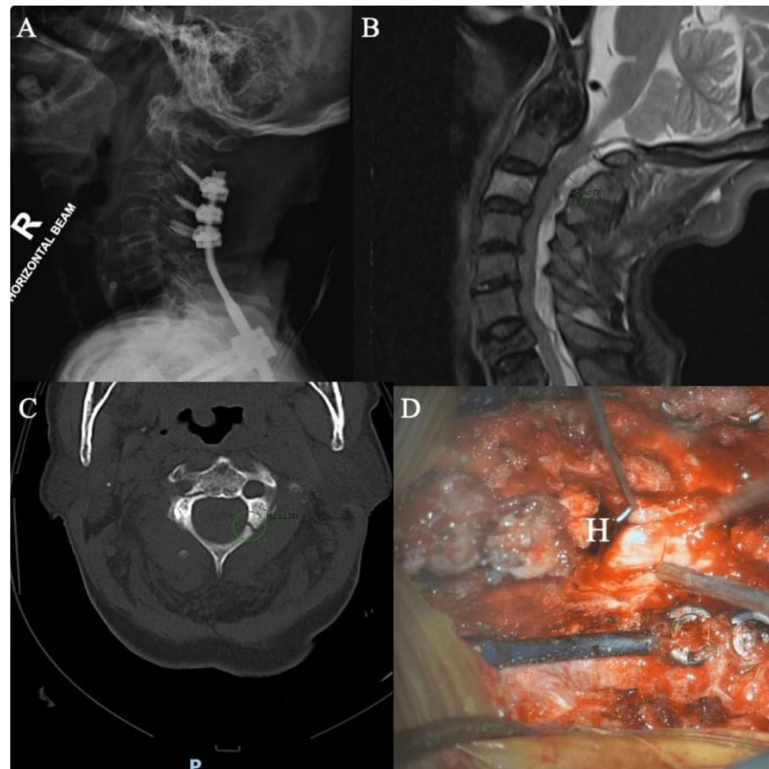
Case no. 1. (A) Lateral cervical X-ray: C2-T4 posterior instrumentation for right C6/7 facet dislocation, (B) Cervical CT: Minimally displaced C2 (atypical hangman) fracture with loosened left C2 screw, (C) MRI-CS: Extensive epidural hematoma from foramen magnum to T1, cord edema at C4-C6, and multi-level stenosis at C3-C6, (D) Intraoperative photo: Hematoma (labeled "H").
